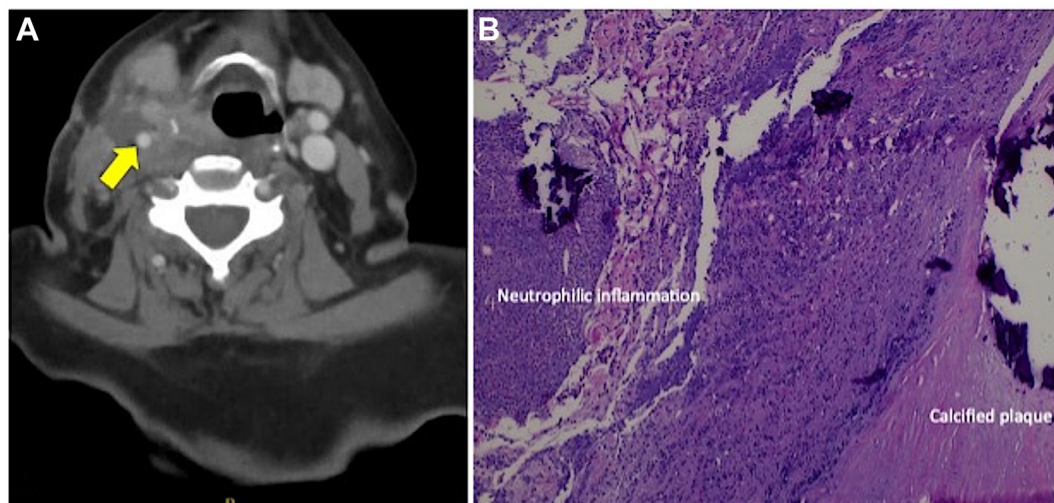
Postoperative computed tomography angiography (CTA) showing patent arterial reconstruction with no surrounding mass (A). Pathology was positive for carotid sheath abscess (B).
